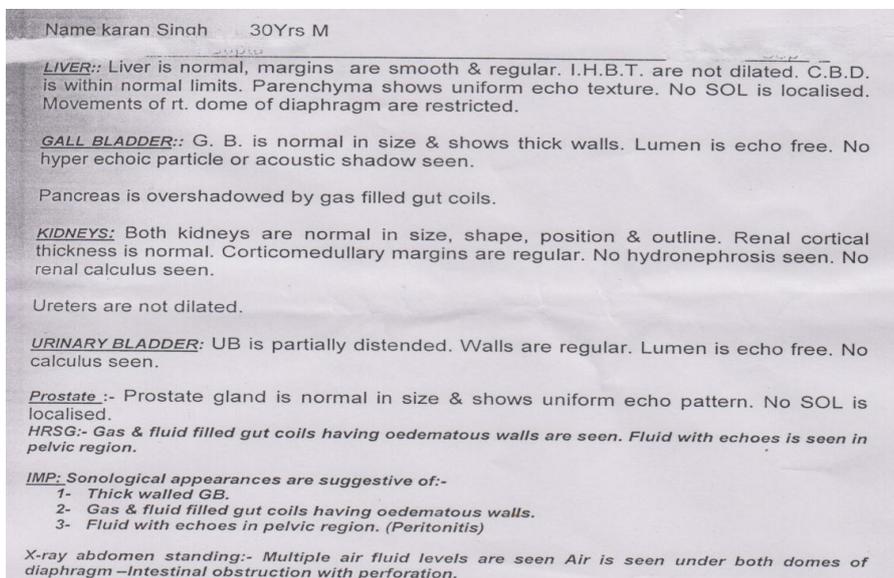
USG and x-ray abdomen report.
